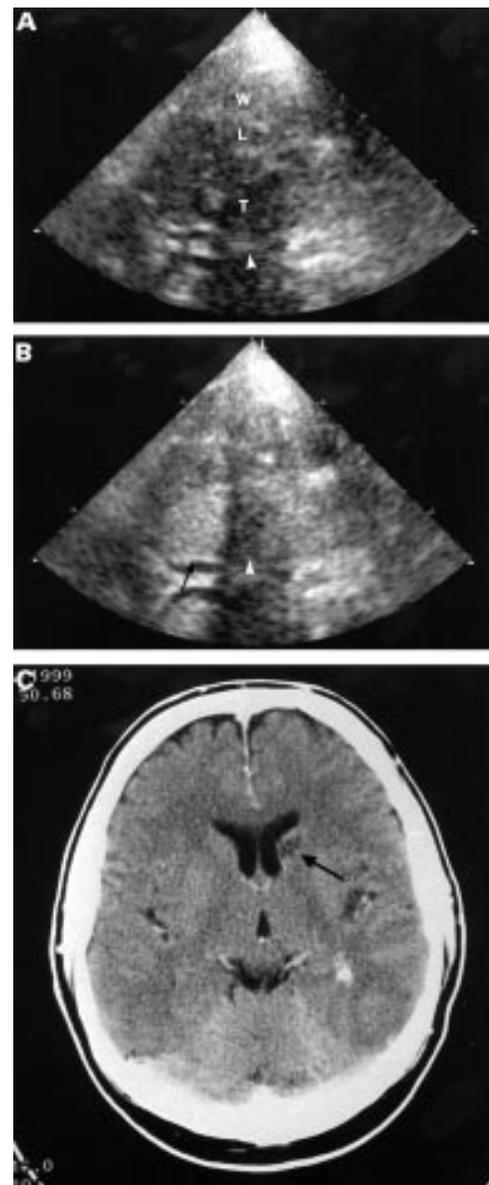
(A, B, and C) Lacunar infarction. (A) Before application of echo contrast. (B) 18 Seconds after echo contrast application; but clear increase of optic intensity in all regions of interest including the ischaemic area (black arrow), asymmetric bone window causes less pronounced signal increase in midparts of the ultrasound sector (white arrow). (C) In CT lacunar infarction affecting the head of the caudate nucleus.
